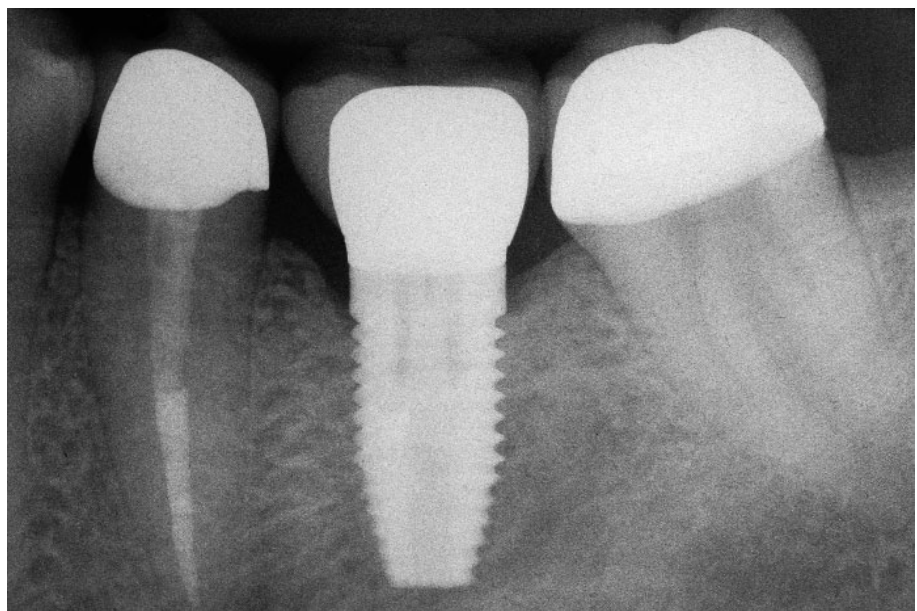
Final radiograph showing individual restorations. (Implant placement by Robert Bressman, DDS, Skokie, IL.)
